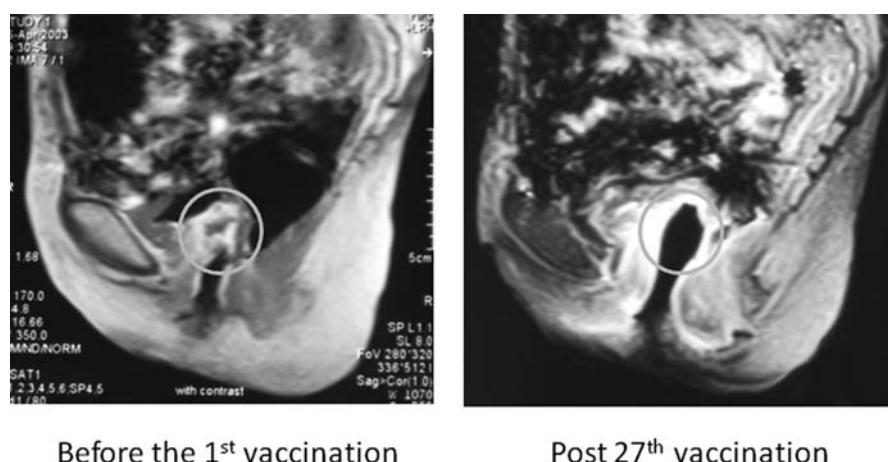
Bladder-vaginal fistula. Magnetic resonance imaging revealed the disappearance of the tumor mass after the 27th vaccination in a patient with advanced cervical cancer (GY-II-004).
